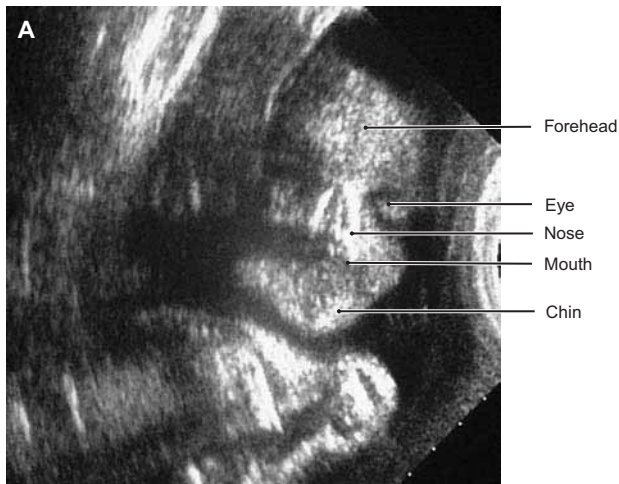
Sonogram of Uterus during the 24th Week of Pregnancy
